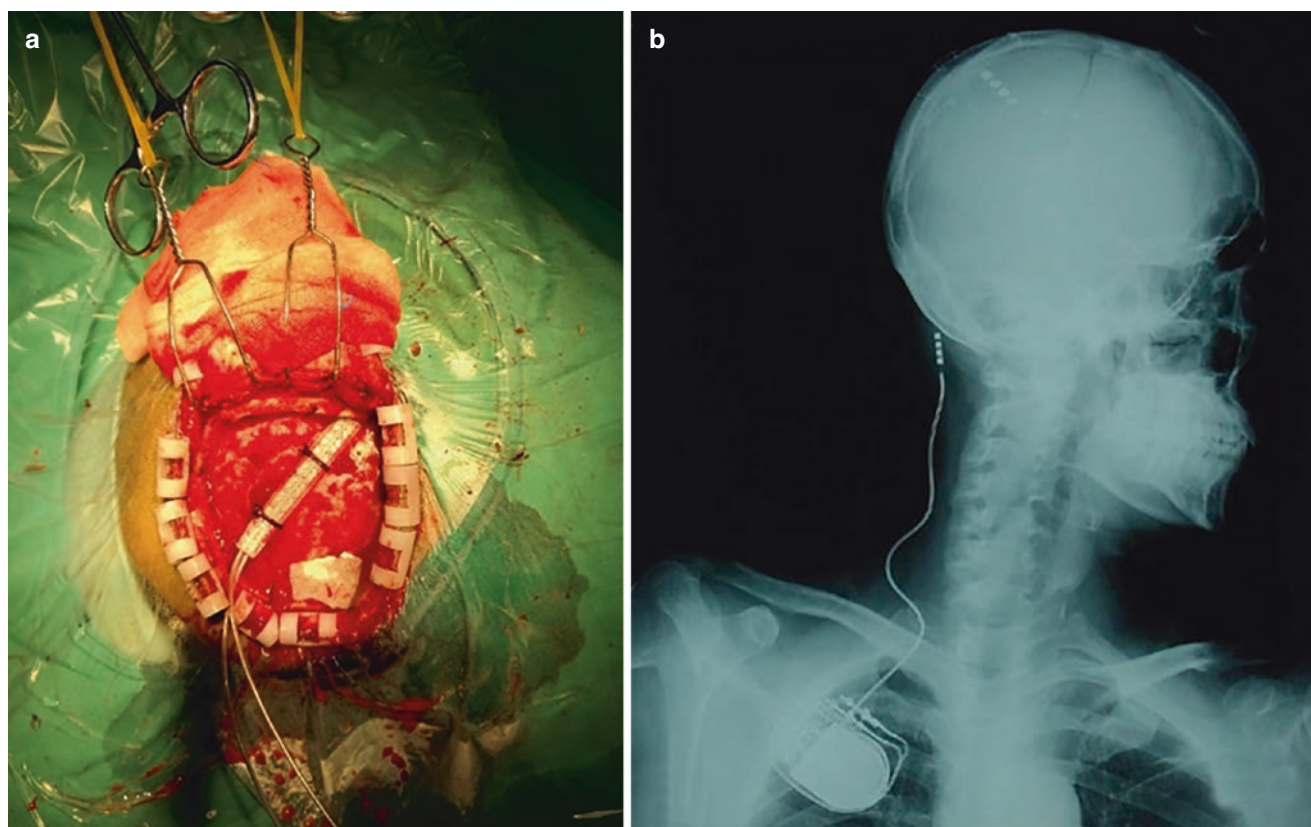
Intraoperative and postoperative photos of MCS. (a) Bone flap craniotomy, after epidural electrical stimulation, the fixed electrodes parallel to the gyrus precentralis; (b) X-ray image after the full set of MCS device placed
